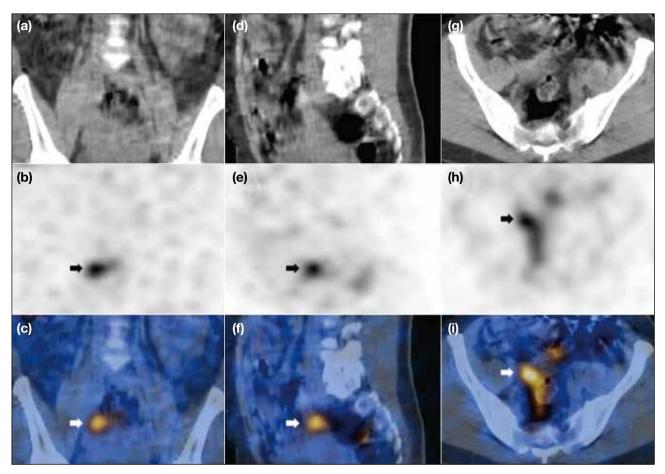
Iodine-131 6-beta-iodomethyl-19-norcholesterol (NP-59) scintigraphy with day 4 (a-c) coronal computed tomography (CT), singlephoton emission computed tomography (SPECT) and fused SPECT-CT images, (d-f) sagittal CT, SPECT and fused SPECT-CT images, and (g-i) axial CT, SPECT and fused SPECT-CT images of pelvis. SPECT and fused images show an abnormal focal increase in NP-59 uptake at the right adnexal region (arrows) that could be distinguished from adjacent physiological large bowel activity.
